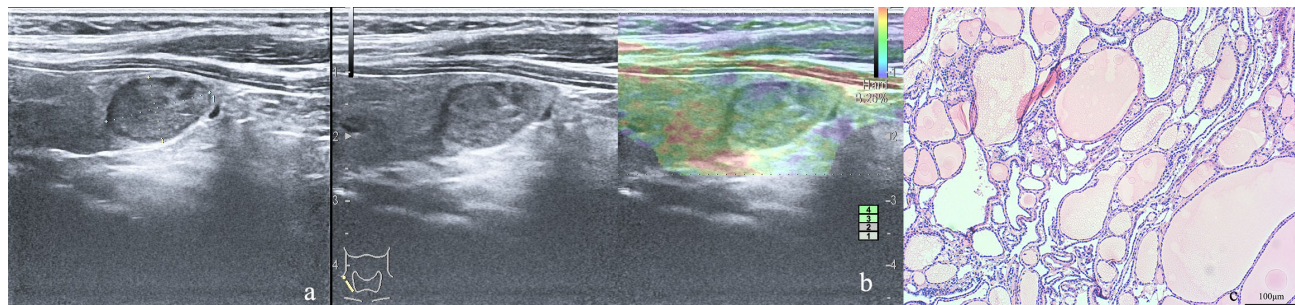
A 50-year-old female patient with a 17 mm nodule. (a) Two-dimensional ultrasonographic features: Solid, hypoechoic, regular margins without calcifications. TIRADS classification: C-TIRADS 4a, ACR-TIRADS 4, K-TIRADS 4. (b) Elastography is mainly green with an elasticity score of 2. Adjusted TIRADS, C-TIRADS 3, ACR-TIRADS 3, K-TIRADS 3. (c) Postoperative pathological results indicating nodular goiter (100 \times).
